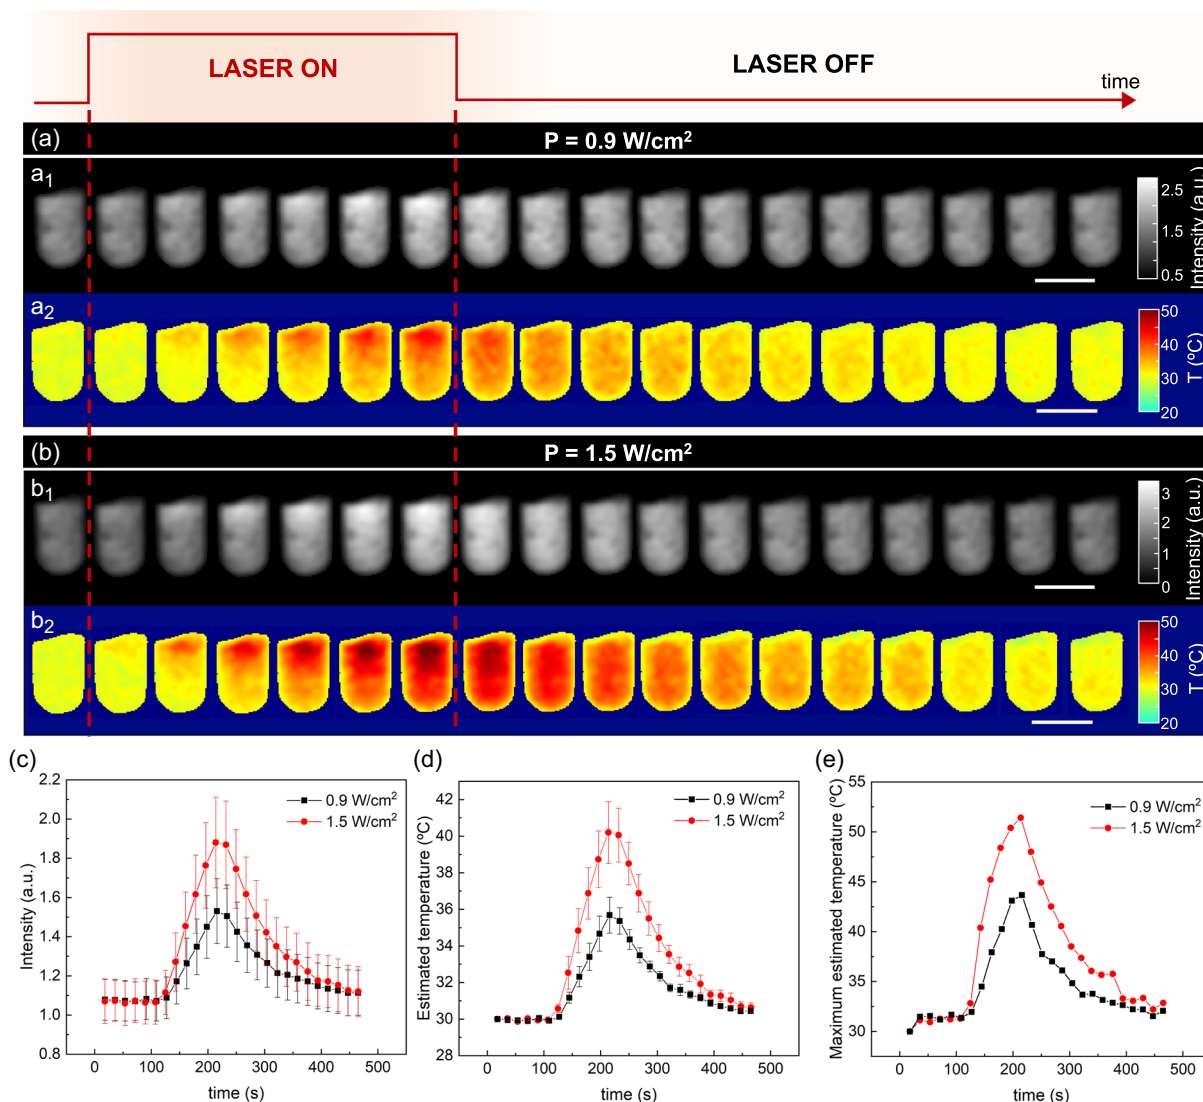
a) 2D T_2^* -weighted images of a 2D slice of the sample (a_1 and b_1) and associated temperature maps (a_2 and b_2) determined through the obtained 2D calibrations with the cellular assembly (150 μg mL⁻¹ incubation concentration of Fe₃Se₄ NPs) before, under, and after NIR irradiation for 120 s at 0.9 W cm⁻² and b) 1.5 W cm⁻² (scale bar = 5 mm); c) variation of the average intensity of the MRI image at the ROI during the laser experiment; d) variation of the average estimated temperature and e) maximum estimated temperature from the images during the laser experiment. The error bars in (c,d) are a measure of the temperature heterogeneity across the ROI. Error bars associated with temperature uncertainty, obtained at thermal equilibrium, are shown in Figure S16 and S17, Supporting Information. Please see the Supporting Information videos with the temporal evolution of the MRI images and temperature maps.
